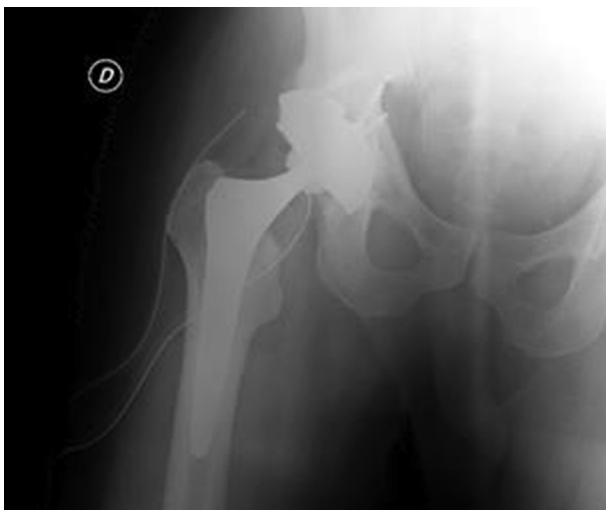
Same case as in Fig. 1. Postoperative pelvic X-ray film: THA with Revision Shell cup, augment and 4 screws.
